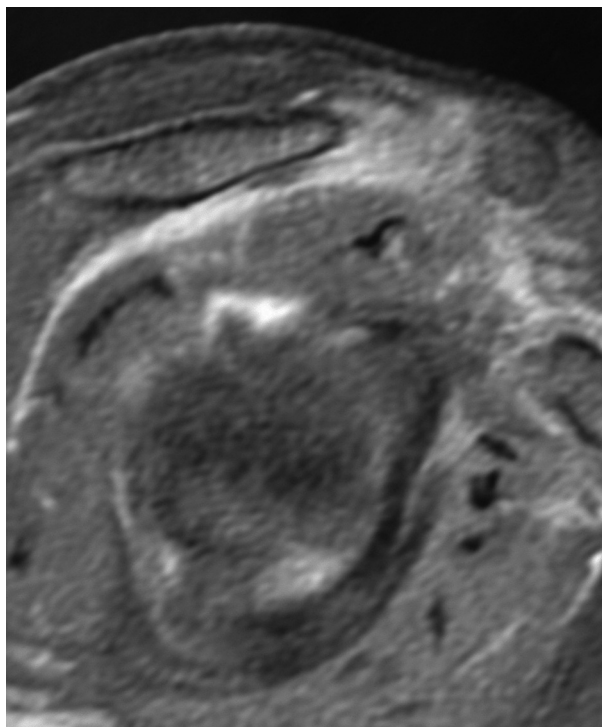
Magnetic resonance imaging, right shoulder, sagittal view, showing complete resection of the lesion (acromioplasty) and resection of the lateral end of the clavicle.
